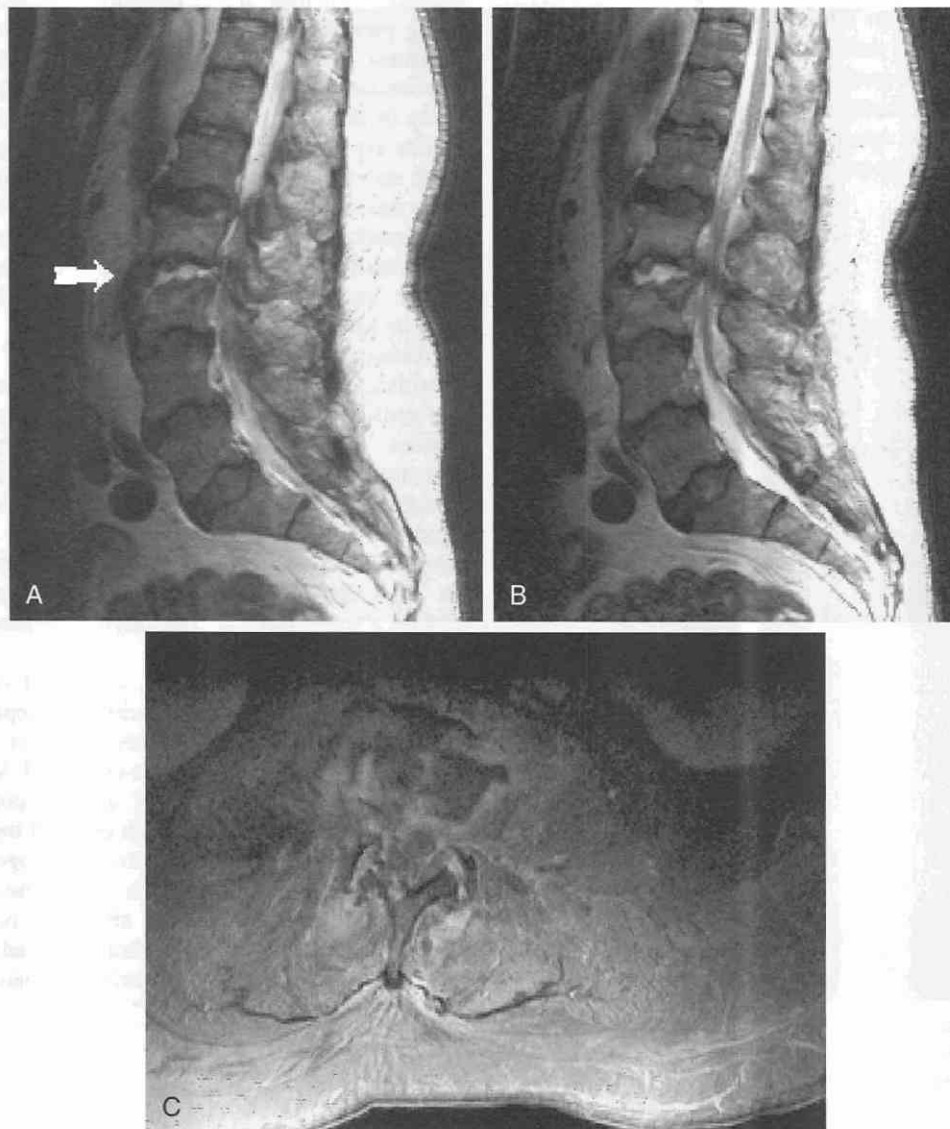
Lumbar disk space infection with osteomyelitis and paraspinal cellulitis. *A* and *B*, Sagittal T2-weighted images through the lumbar spine. Bright signal is associated with the L2-3 intervertebral disk. This is the hallmark of diskitis on an MRI scan (*arrow*). *C*, Post-contrast-enhanced axial T1-weighted image. Enhancement can be visualized in and around the L2-3 interspace, as well as in the paraspinal soft tissues and within the spinal canal. These represent paraspinal and epidural cellulitis. If left untreated, they could progress to abscess formation.
